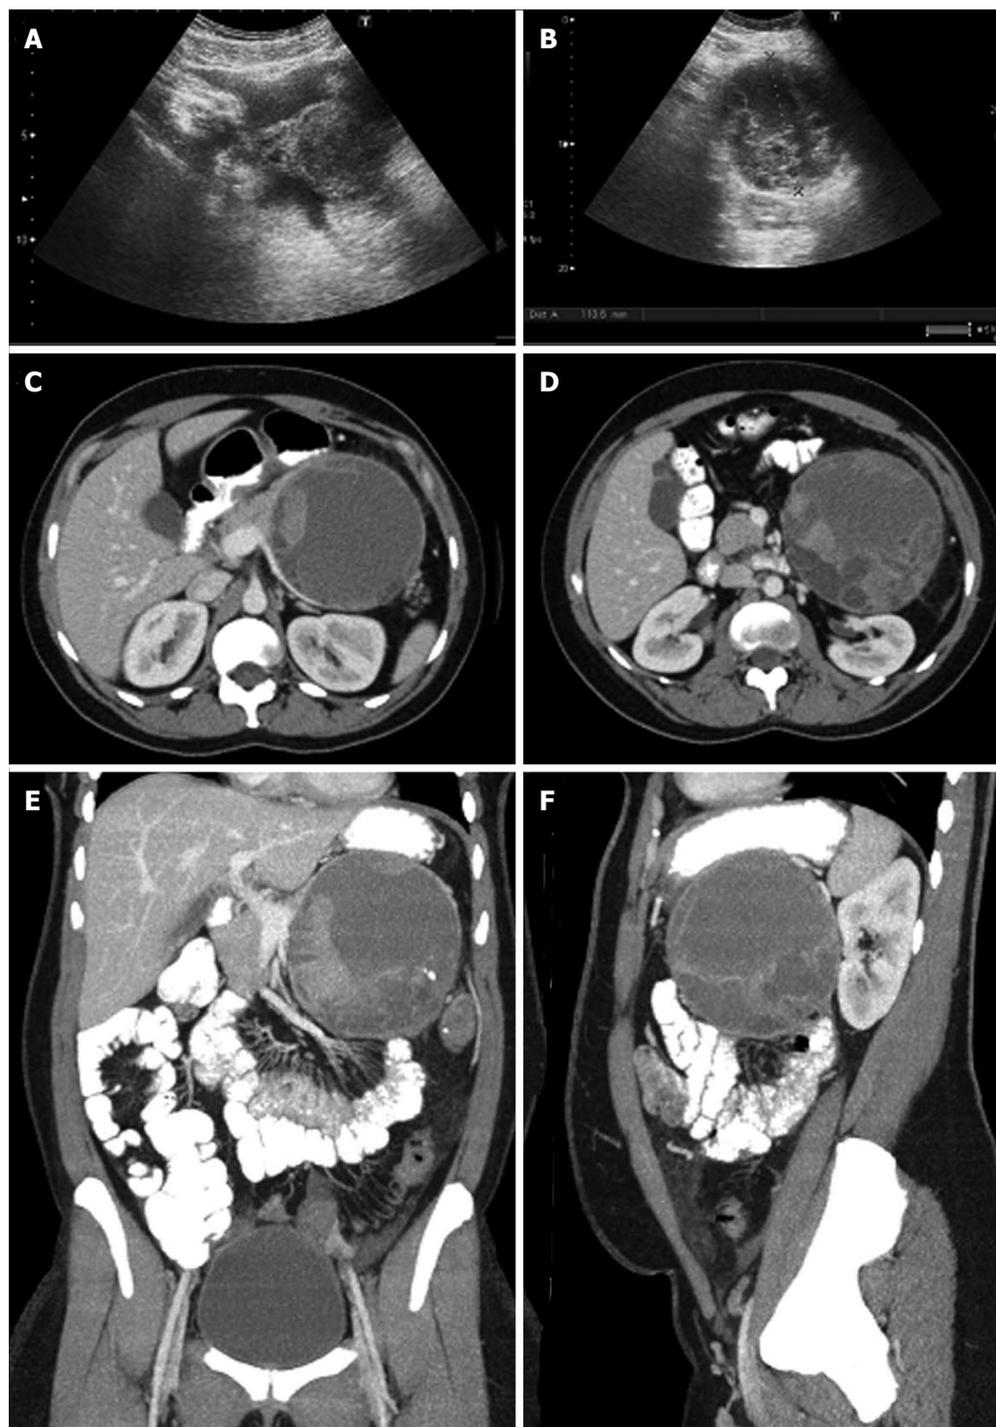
Ultrasound and multidetector computed tomography images. On ultrasound (A, B) a hypoechoic multilocular mass with well-definable internal septations and posterior acoustic enhancement can be seen. Contrast-enhanced multidetector computed tomography images (C-F) show a big round to slightly lobulated mass with an enhancing capsule and different levels of attenuation within the cyst cavities are seen. Some enhancing components are also detectable.
